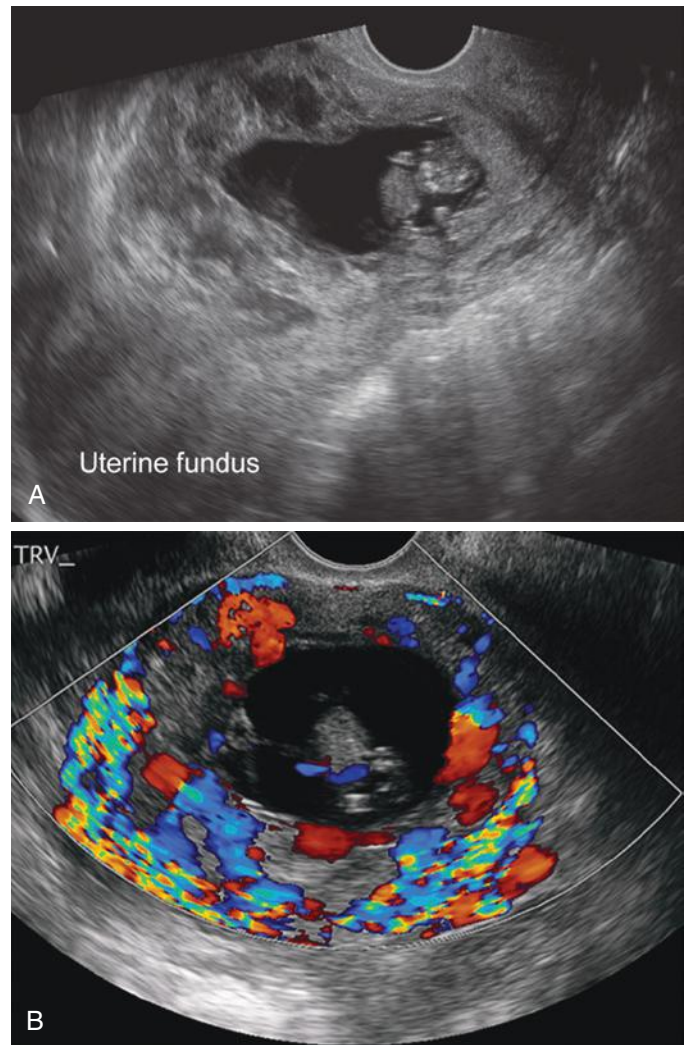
Cesarean scar pregnancy with echolucent placental spaces. A, This transvaginal image in the sagittal plane at 10 weeks' gestation depicts numerous hypoechoic areas within the placenta. Not only has the gestational sac implanted inferior and anterior within the lower uterine segment, but also the sac appears to bulge or "balloon" outward from the uterine serosa. B, Color Doppler sonographic imaging demonstrates prominent turbulent flow within the echolucent areas. This cesarean scar pregnancy was treated with methotrexate and evacuation of the uterus.
